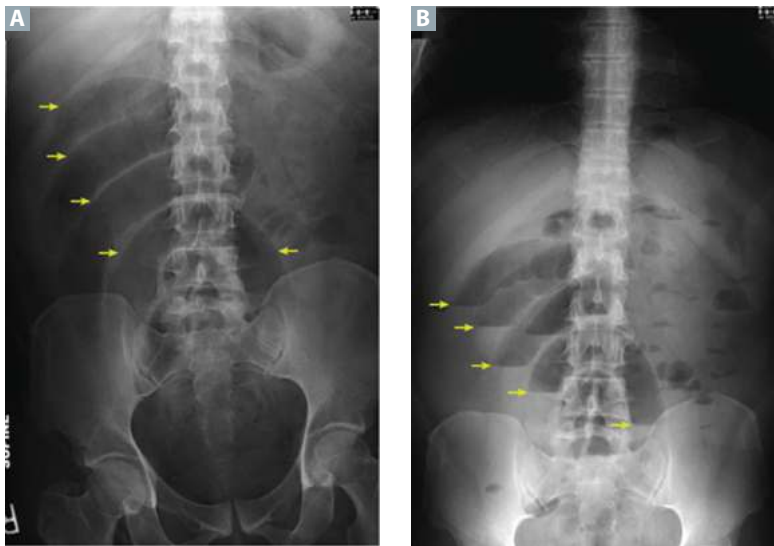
Abdominal plain films. Supine (A) and upright (B) abdominal plain films demonstrate multiple loops of dilated small bowel (*arrows in A*) with air/fluid levels (*arrows in B*) in the right abdomen, suggestive of small bowel obstruction; this finding can also be seen as an unusual sign of acute appendicitis. Intestinal malrotation was not considered at this time. (Reproduced with permission from Welte FJ, Grosso M. Left-sided appendicitis in a patient with congenital gastrointestinal malrotation: A case report. *J Med Case Rep.* 2007;1:92..)
